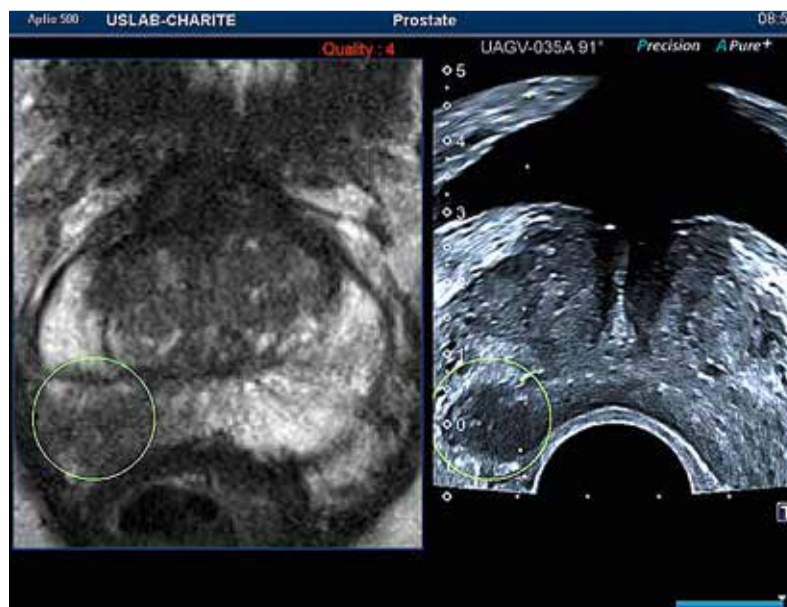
Image fusion, the green circle shows the tumour in both MRI (right) and US
